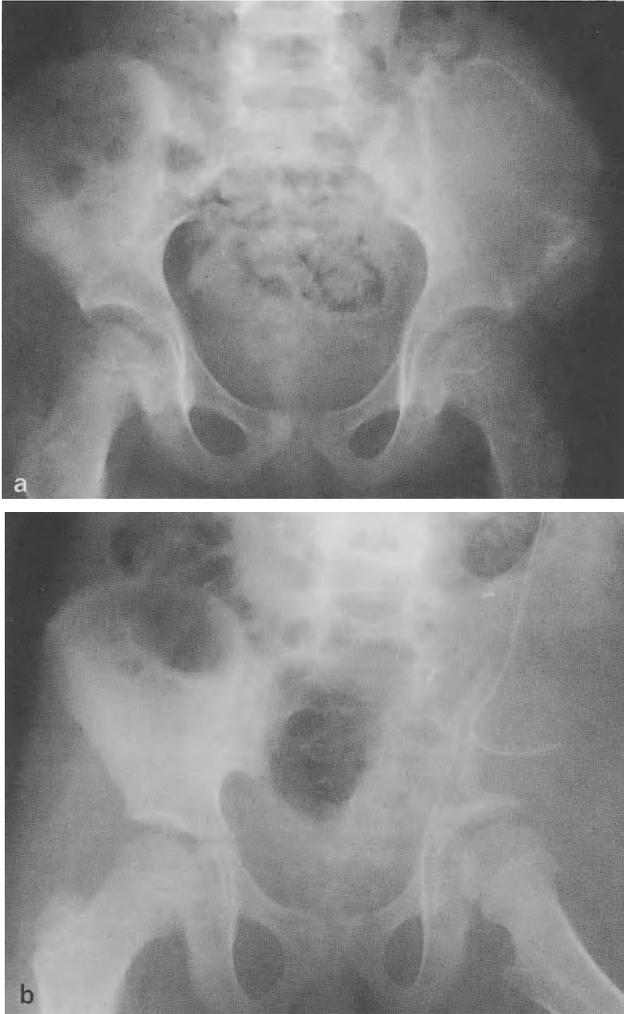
a Plain radiograph of pelvis of child with a large Ewing's sarcoma of the iliac bone. b Plain radiograph of pelvis following chemotherapy and surgery; same patient as in Figs. 3 and 4a
